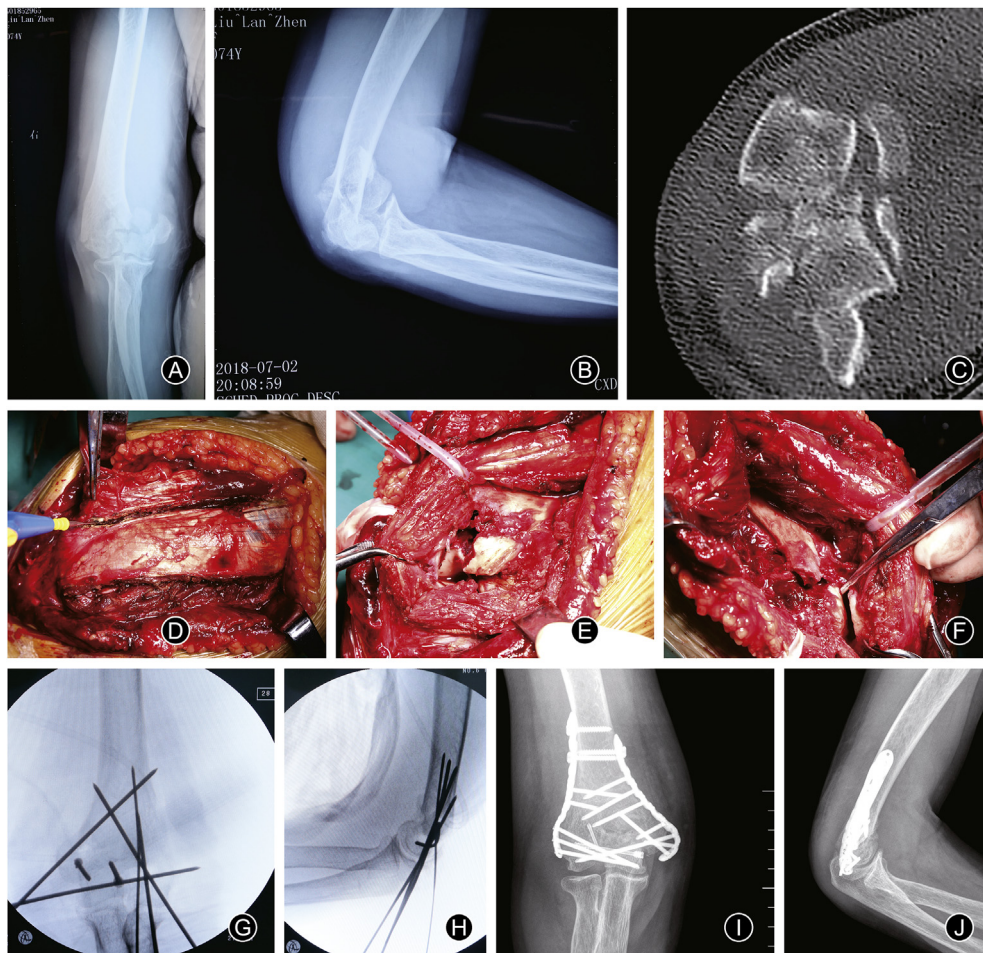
Imaging and intraoperative findings of one 62-year-old female with type C3 distal humerus fracture. (A, B and C) Radiograph and CT scan displayed a comminuted distal humeral fracture; (D) Medial aponeurosis can be stripped from olecranon to become a larger medial window; (E) Surgical field of view from lateral window of BTT approach; (F) Surgical field of view from medial window of BTT approach; (G and H) distal humeral fracture was temporarily fixed with Kirschner wires and identified by AP and lateral view by fluoroscopy; (I and J) Postoperative radiography showed good reduction and rigid fixation.
